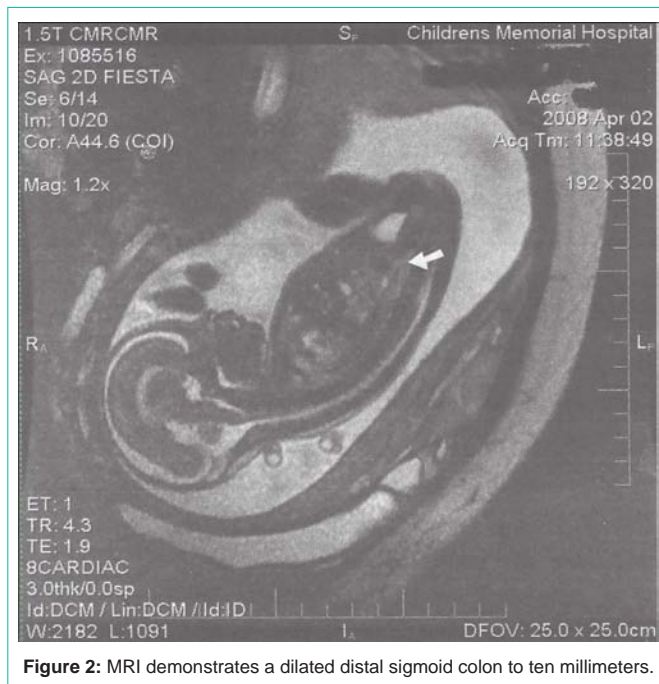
MRI demonstrates a dilated distal sigmoid colon to ten millimeters.
